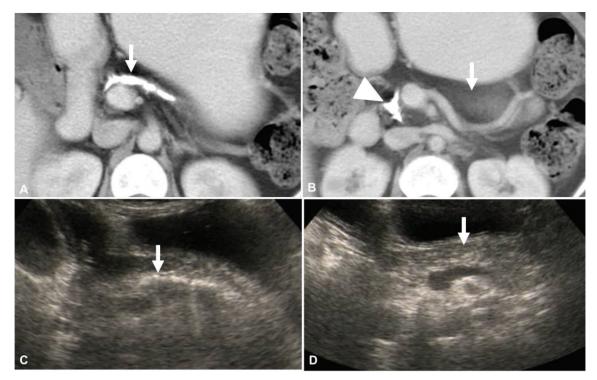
An 18-year-old male patient with tropical chronic pancreatitis (TCP) and diabetes mellitus. Contrast CT axial images (A, B), Ultrasonography images (C, D) show pancreatic parenchyma completely replaced by fat (B, arrow). Echogenic fat on ultrasound can mimic normal pancreas (D, arrow). Note the dilated main pancreatic duct (MPD) with intraductal calculi (A, C arrow).
